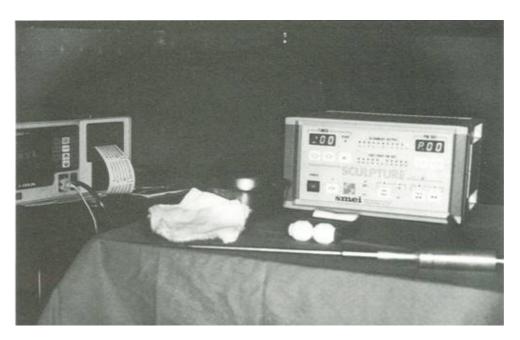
Dr. Zocchi's ultrasound equipment employed in the treatment of the super6cial layers and for stimulation of the inner surface of the dermis.
